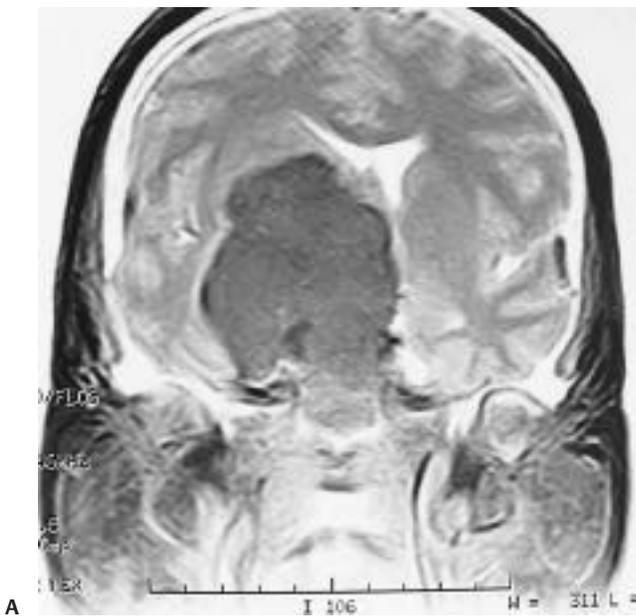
(A) Coronal and (B) sagittal T1-weighted magnetic resonance imaging of a giant type I clinoidal meningioma engulfing the right internal carotid artery and its branches. (continued)
